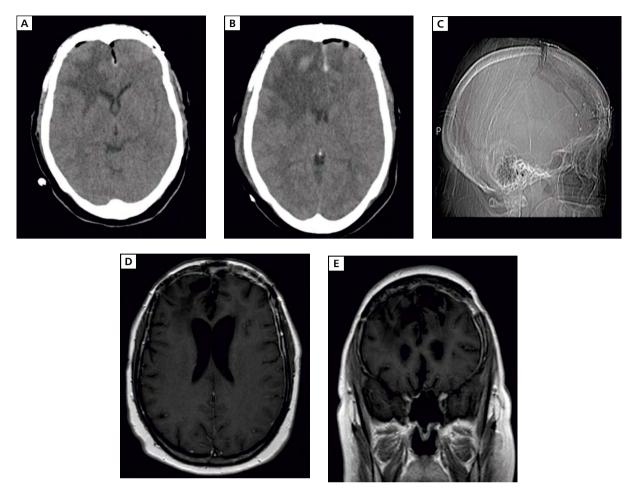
Postoperative brain CT scan (A) of the patient after 1 day revealed diffuse bi-frontal edema (B) which elevates the fixed bone flap (C). On one year follow-up, MRI with gadolinium (D, E) revealed no remnant or recurrence of the tumor
